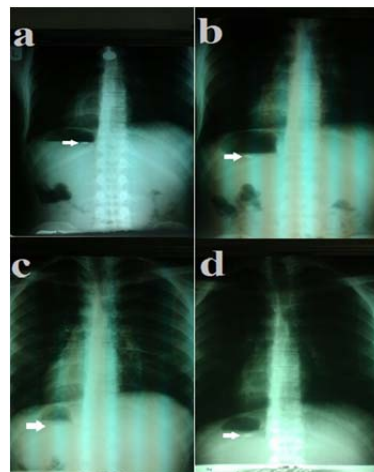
X-ray photographs of the BaSO₄-loaded floating tablets in the stomach at (a) 0.5h, (b) 1h, (c) 3h, and (d) 5h.
